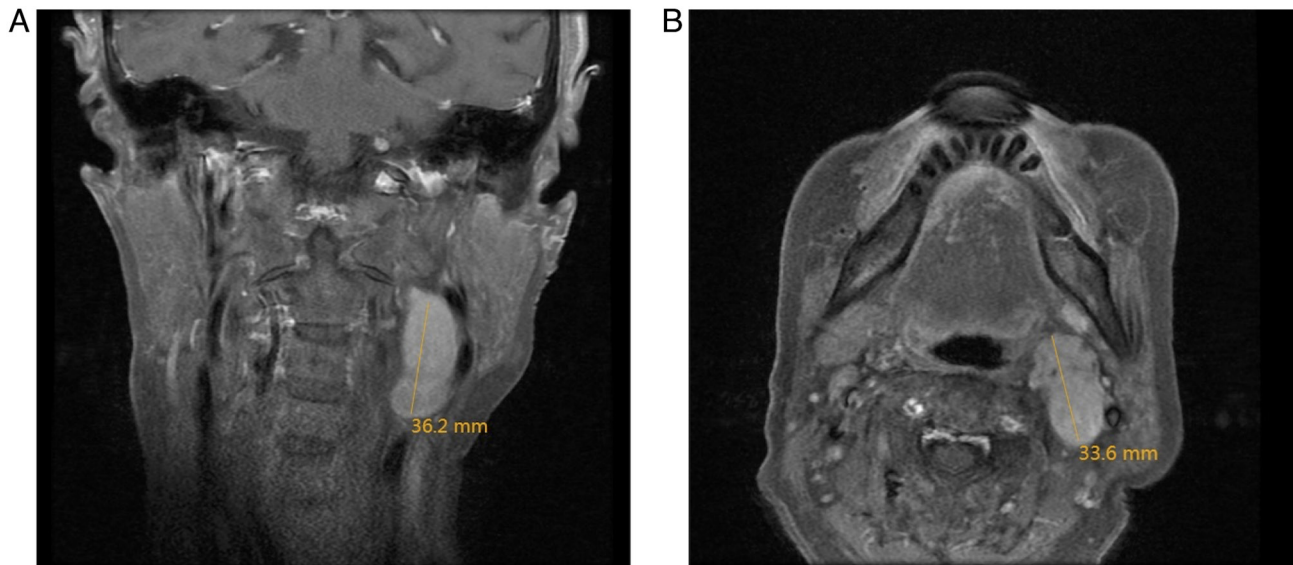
Cervical MRI enhancement in the (A) coronal and (B) horizontal plane showing a heterogeneous and markedly enhanced mass in the left cervical level Ib and II regions.
